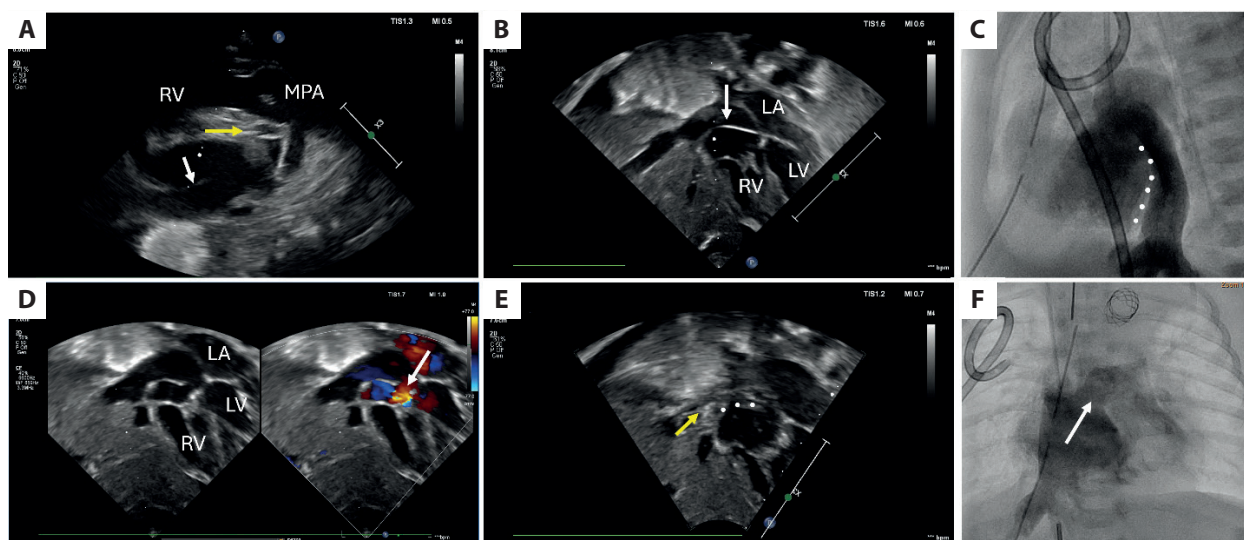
TTE and angiography showing cor triatriatum dexter in a patient with aortic atresia and well-developed two chambers. A. TTE parasternal long axis view showing aortic atresia with hypoplastic ascending aorta (yellow arrow), wide pulmonary artery, and prominent EV (white arrow) dividing RA into 2 chambers. B. TTE subcostal view showing EV dividing the right chamber into upstream chamber with venous flow and downstream chamber with appendage and tricuspid valve. C. IVC angiography in lateral view showing prominent EV (white dots) with division of RA into 2 chambers. D. TTE subcostal 4-chamber view with color Doppler as comparison, showing incomplete membrane of EV with small communication and laminar flow. E. TTE subcostal view showing saline-agitated inflow with microbubbles (yellow arrow) in upstream chamber. White dots indicate prominent EV. F. IVC angiography showing right-to-left shunt *via* atrial septal defect (white arrow)
